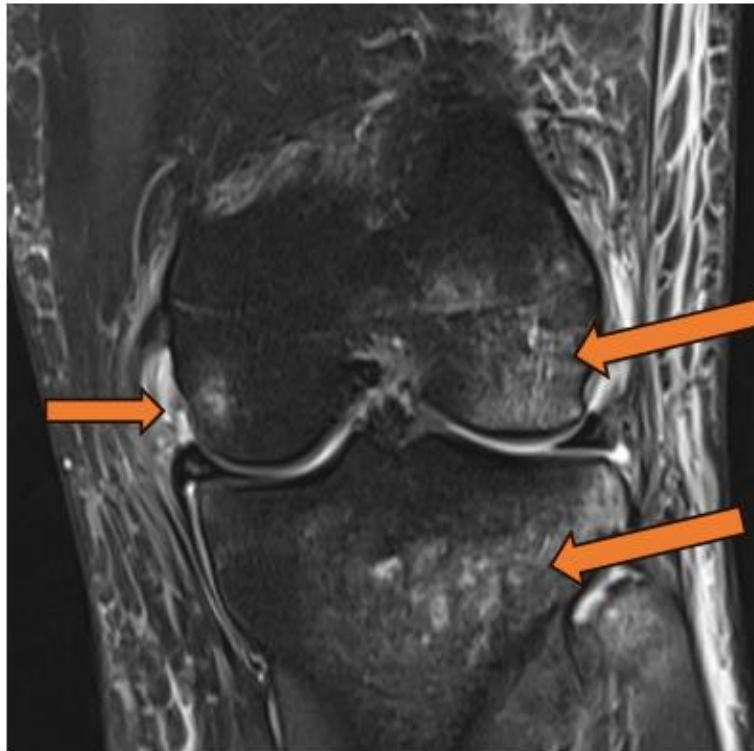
MRI right knee joint, STIR sequence coronal section, shows subchondral bone marrow contusions within the Tibial and Femoral lateral condyles and a partial MCL tear
